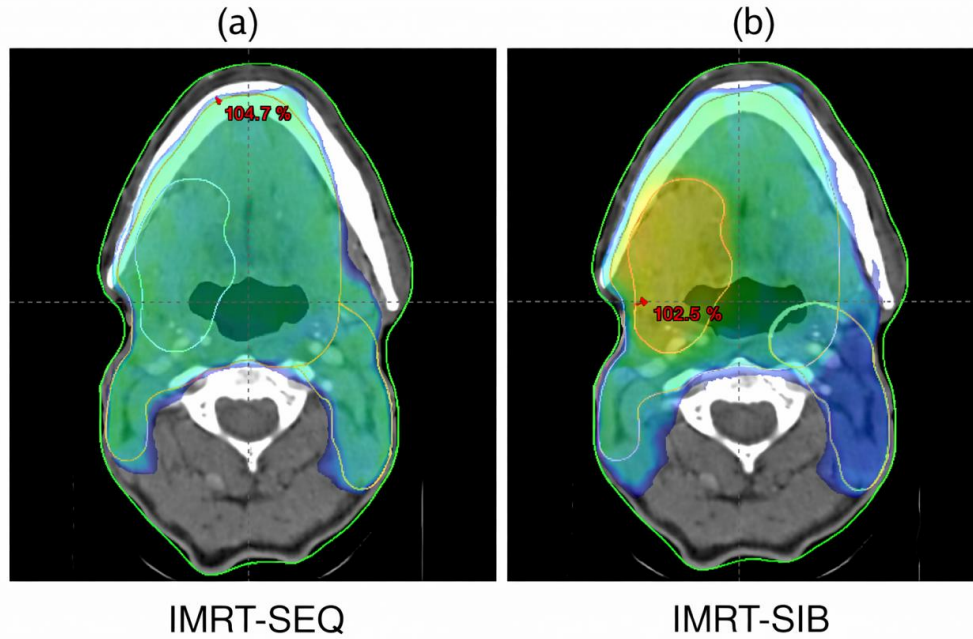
Representative axial CT slice showing isodose distribution for (a) IMRT-Sequential Boost and (b) IMRT-Simultaneous Integrated Boost plans.
